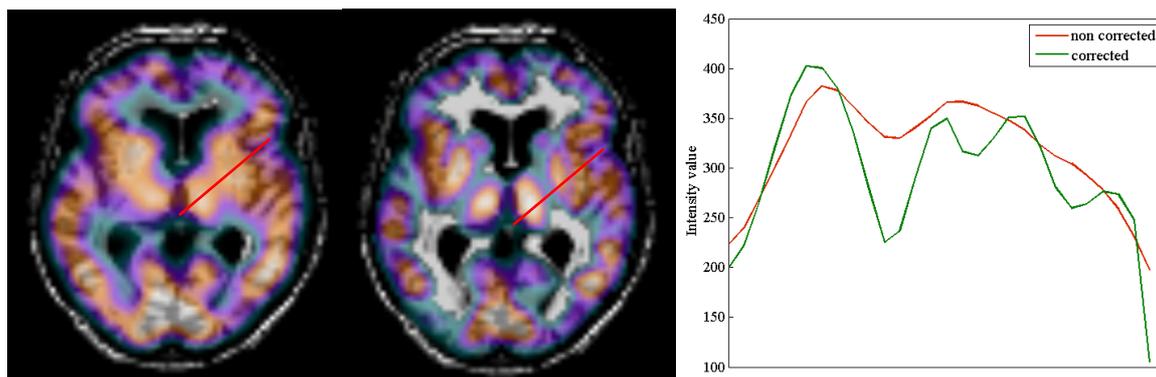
Brain perfusion images before PVC (left) and after PVC (center) overlaying the anatomical MR which has been resliced in the SPECT space. Right: profile along the basal ganglia (red line on the images).
